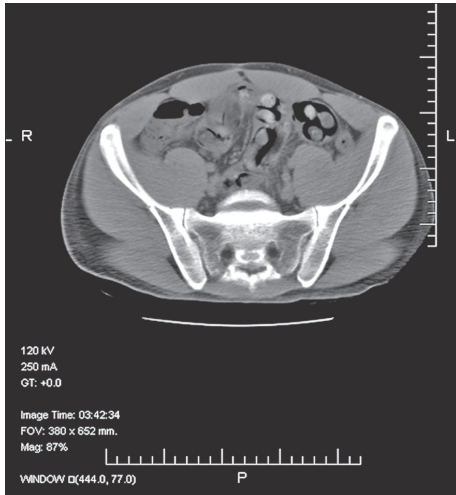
CT image of the abdomen demonstrates multiple drug packages in the colon.
